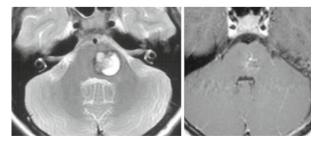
Preoperative (*left*) and postoperative MRI (*right*) of a 13 years-old female patient who presented with a double vision and gait ataxia. The cavernous malformation was removed by microsurgical resection via a left-sided infratentorial far lateral approach as shown in Fig. 4
